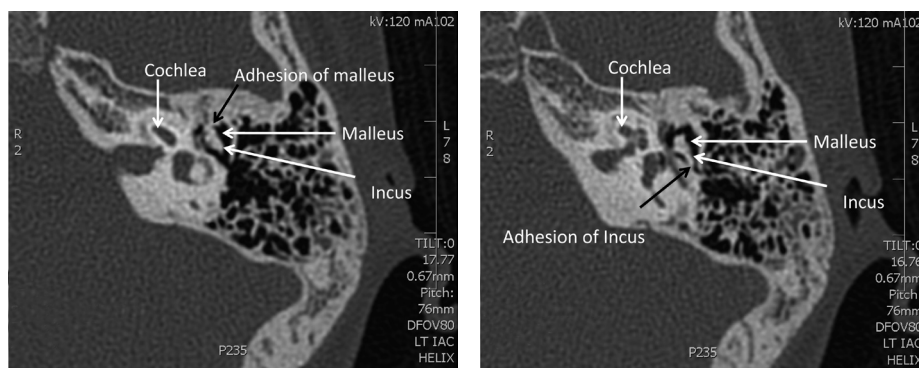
Left: This axial CT of the left temporal bone demonstrates the adhesion of the malleus head to the surrounding bone. Right: This axial CT of the temporal bone shows fixation of the incus. The normal malleus head and incus body (which together look like an ice-cream cone) should be surrounded by black areas (air and thin ligaments). In this patient, there is a white (bony) adhesion to surrounding bone.
